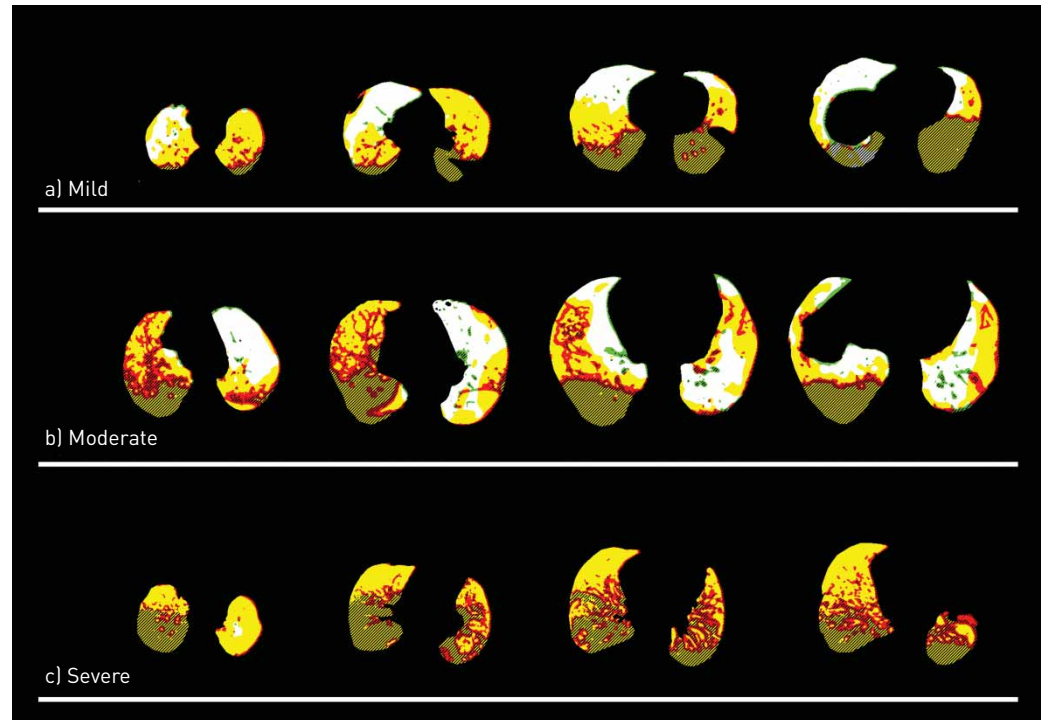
Interaction between $[^{18}\text{F}]\text{FDG}$ uptake rate and lung inhomogeneity in mild, moderate and severe ARDS. Lung compartments at different lung levels from the apex to the base. Lung compartment colour code: white, homogeneous with normal $[^{18}\text{F}]\text{FDG}$ uptake rate; green, inhomogeneous with normal $[^{18}\text{F}]\text{FDG}$ uptake rate; yellow, homogeneous with high $[^{18}\text{F}]\text{FDG}$ uptake rate; red, inhomogeneous with high $[^{18}\text{F}]\text{FDG}$ uptake rate; shadowed areas represent not inflated tissue. Patient a) mild ARDS (polytrauma with bilateral pulmonary contusion), $\text{PaO}_2/\text{FiO}_2$ 257, ICU outcome: alive. Patient b) moderate ARDS (bacterial pneumonia: *Streptococcus pneumoniae*), $\text{PaO}_2/\text{FiO}_2$ 172, ICU outcome: alive. Patient c) severe ARDS (bacterial pneumonia: *Staphylococcus aureus*) $\text{PaO}_2/\text{FiO}_2$ 87, ICU outcome: dead. See online supplementary material for images of all the patients. $[^{18}\text{F}]\text{FDG}$: $[^{18}\text{F}]\text{2-fluoro-2-deoxy-D-glucose}$; ARDS: acute respiratory distress syndrome; PaO_2 : arterial oxygen tension; FiO_2 : inspiratory oxygen fraction; ICU: intensive care unit.
